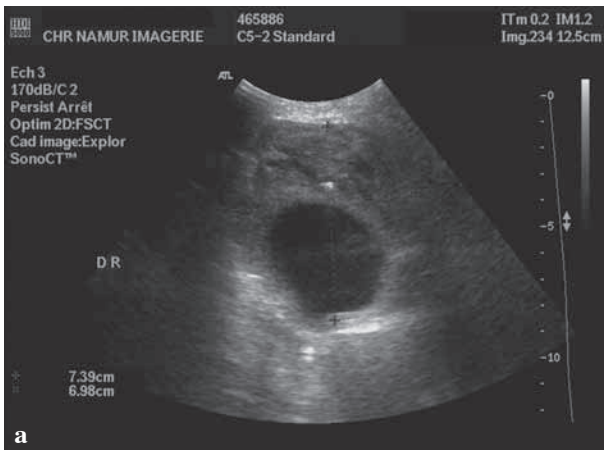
Doppler ultrasound showing the popliteal pseudoaneurysm (a) and corresponding view on axial CT angiogram (b) (case 3).
